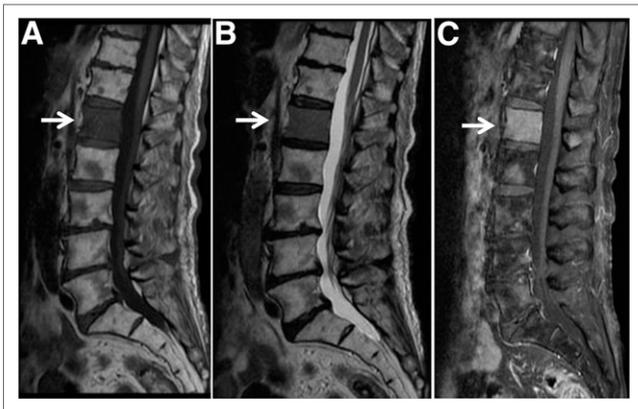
L1 vertebral body (arrows) showing decreased signal intensity on both T1-weighted (A) and T2-weighted (B) MRI and enhancement with gadolinium (C).
